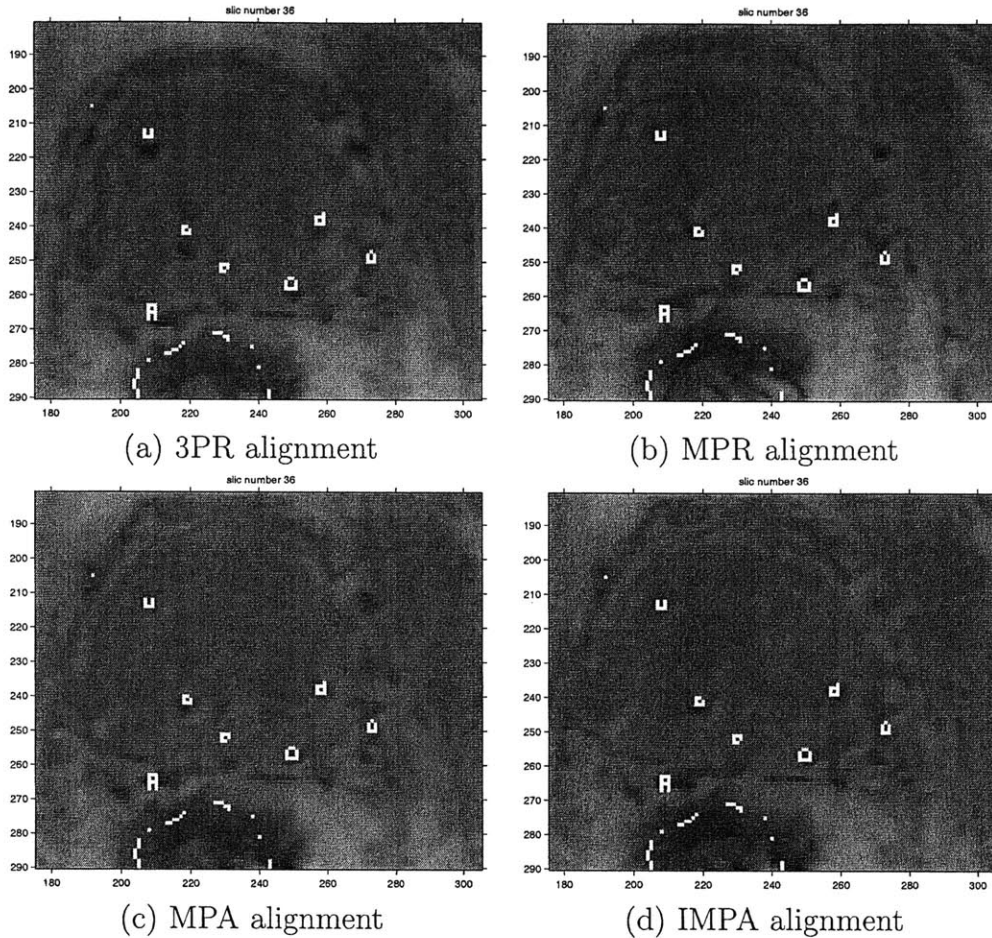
This figure shows Aligned MR images with overlaid CT edges. CT images are fixed, while MR images are reformatted according to 3PR, MPR, MPA, and IMPA registration techniques. These images are mid-volume axial slices of the volumes, zoomed in on the prostate capsule. Bright spots in the image correspond to CT seeds. Partially obscured or closely neighboring these white spots are slightly larger dark spots which generally represent seeds in MR. 3PR (a) shows some slight vertical errors in aligning the dark MR seeds with the light CT seeds. MPR (b) clearly improves on this in the leftmost seeds. MPA (c) and IMPA (d) are expectedly similar, and improve on both 3PR and MPR alignments, as can be seen over all the seeds.
